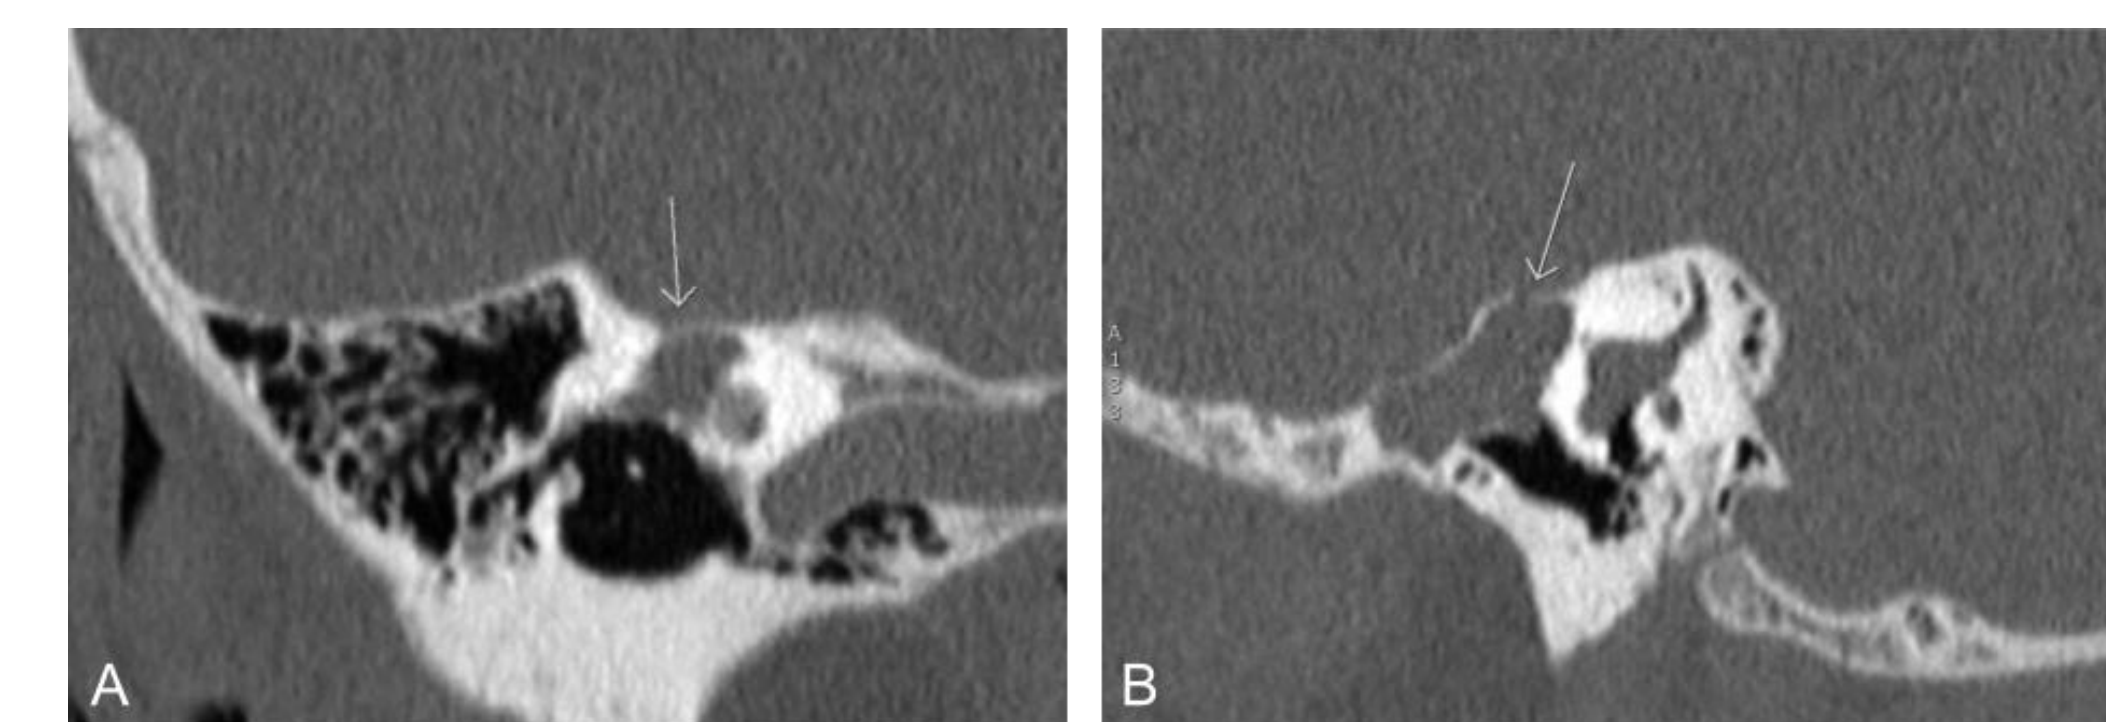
(A) Coronal noncontrast CT image of patient 2 demonstrating lesion in the labyrinthine segment of the facial nerve. (B) Sagittal noncontrast CT image.
